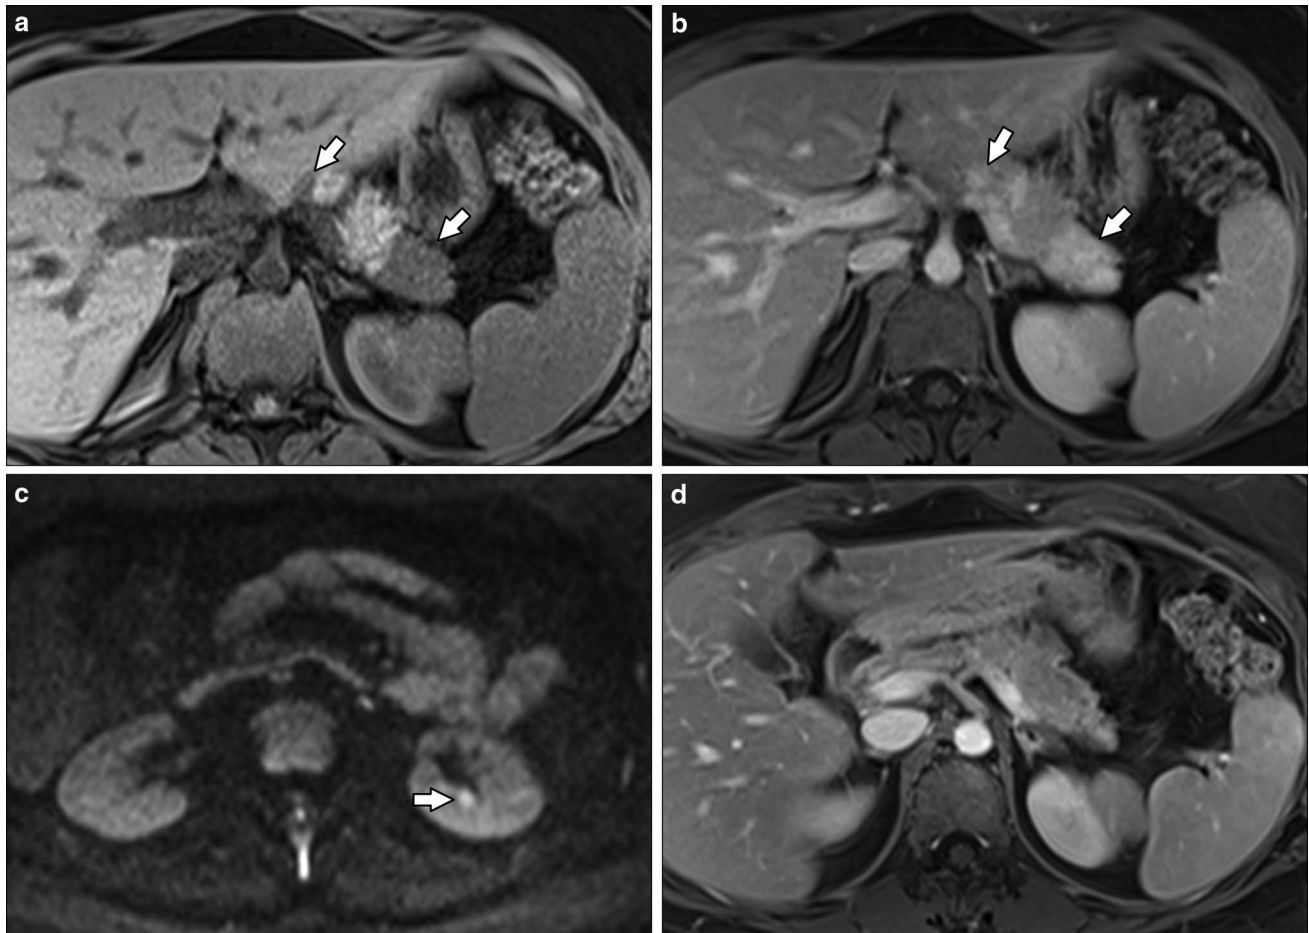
A 30-year-old female with a pancreatic mass seen during a prenatal ultrasound and normal serum IgG4. a Axial T1-weighted FS image shows T1 hypointense lesions in the pancreatic body and tail. b Axial T1-weighted FS delayed contrast-enhanced image shows that lesions are hyperenhancing relative to the pancreas. c Diffusion-weighted MR images ($b800 \text{ s/mm}^2$) show subtle focal lesions within
